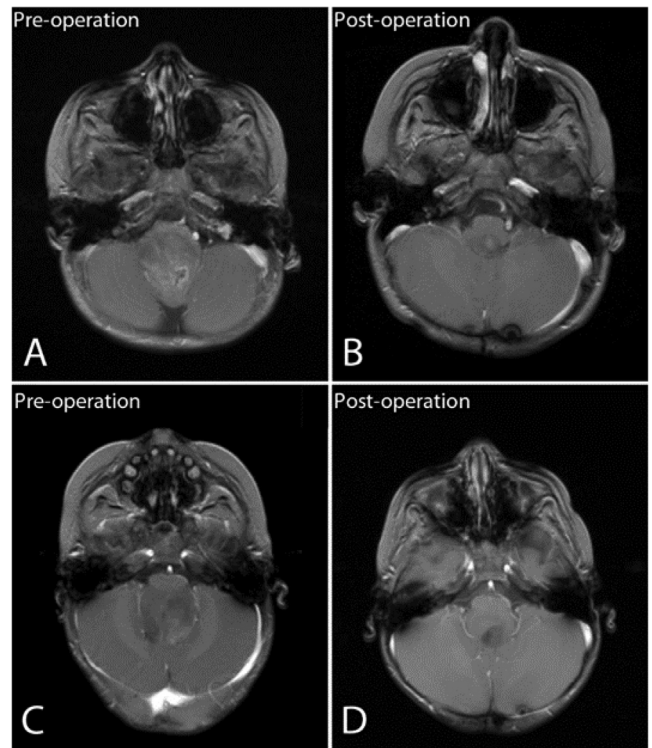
Pre- and post-operative head axial injected T₁-weighted MRI sequences of cases 1 and 2 with dorsally exophytic bulbar tumors. (A) A sequence in case 1 showing a dorsally exophytic bulbar tumor with partial enhancement. (B) An early post-operative sequence in case 1 showing a small tumor residue and no local complication. (C) A sequence in case 2 showing a dorsally exophytic bulbar tumor with partial enhancement. (D) An early post-operative sequence in case 2 showing a small hypo-intense non-enhancing tumor residue on the right dorsal part of the bulba without any local complication.
